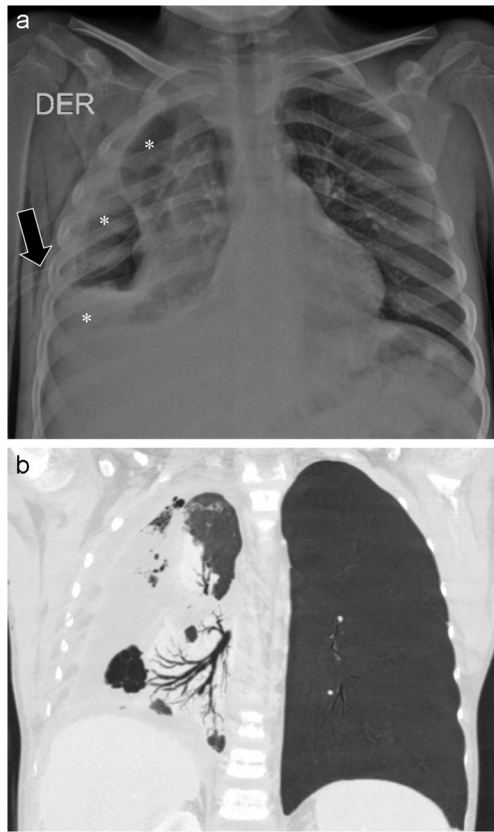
A 9-year-old boy presented with fever and cough was misdiagnosed and treated for complicated pneumonia with pulmonary abscess and right empyema. a Chest radiograph reveals a right hydro-pneumothorax (asterisks) with a chest tube (black arrow) in place. b Coronal CT reformatted image demonstrates a complicated hydatid cyst connected to bronchi (white arrow), which was confirmed during the surgical procedure
